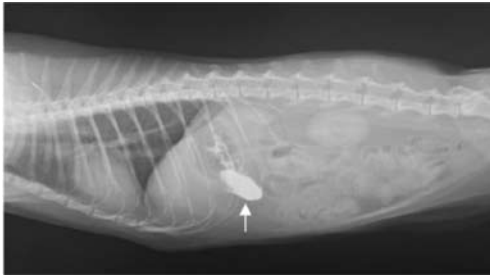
Barium sulfate contrast radiograph indicating obstruction
